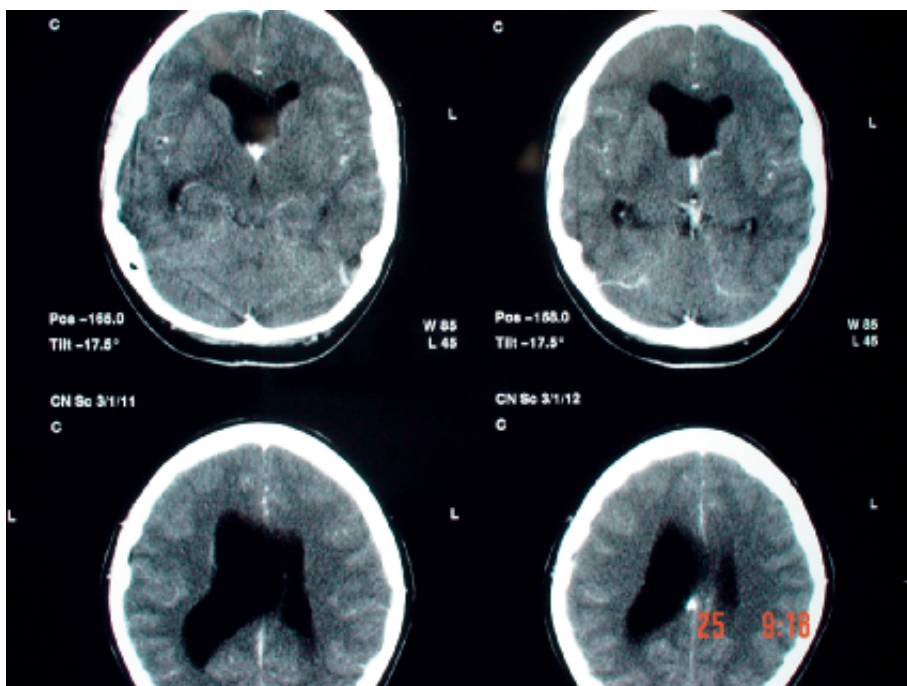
CT scan of the brain shows the enlarged lateral ventricle on the right side along with calcification of the falx cerebri.
